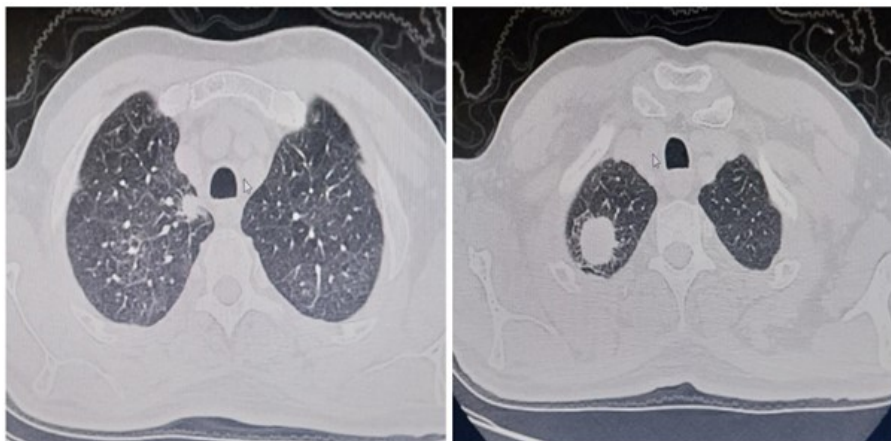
Chest CT images showing a superior right lobar tumoral mass with a nodule in the same lobe
